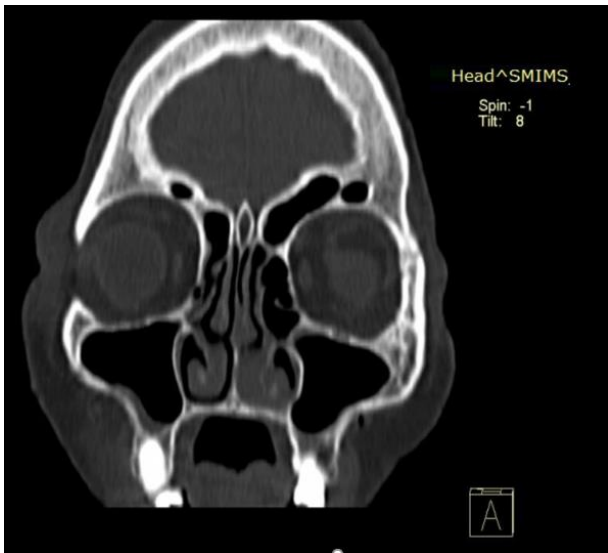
coronal section of CT PNS shows bilateral supraorbital cell.
